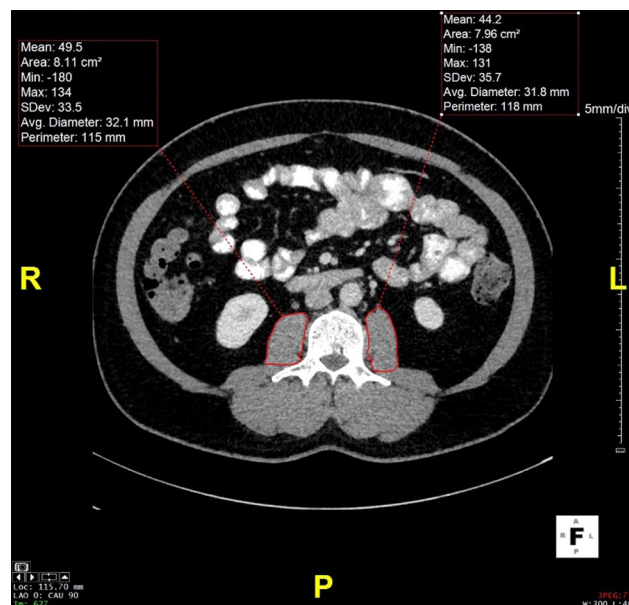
Representative psoas muscle index [psoas muscle area/height (m^2)] measurement using cross-sectional computed tomography at the third lumbar level (L3)
